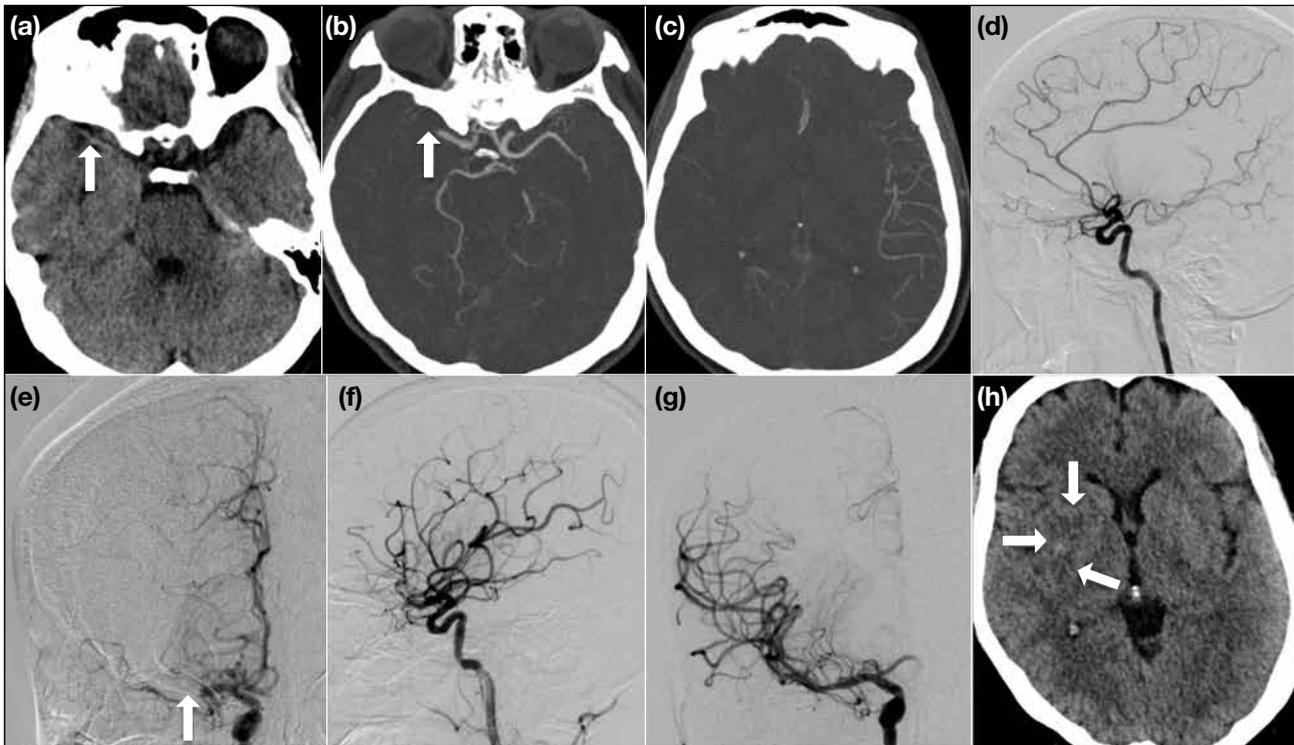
A 56-year-old woman with good past health presenting with acute left-sided weakness and numbness. (a) Plain computed tomography (CT) scan of the brain demonstrated hyperdense right middle cerebral artery (MCA) sign (arrow), suggestive of acute right MCA thrombosis. (b,c) CT angiogram confirmed truncation of right M1 (arrow), with markedly decreased vascularity in right MCA territory and poor collaterals. (d,e) Cerebral digital subtraction angiogram (DSA) showed occlusion of right M1 (arrow) with absent distal flow. Thrombectomy with ADAPT (A Direct Aspiration First Pass Technique), using 5MAX ACE catheter and Penumbra aspiration pump was performed for 2 minutes. (f,g) Post-thrombectomy cerebral DSA showed restoration of the right MCA blood flow with no residual filling defect detected (Thrombolysis in Cerebral Infarction grade 3). Right A1 was taken over by contralateral anterior cerebral artery as confirmed by DSA of the left common carotid artery (not shown). (h) Follow-up plain CT scan of the brain showed only a small area of infarct in the right basal ganglia (arrows). The patient made an uneventful recovery and was discharged 10 days after the stroke, with modified Rankin scale score and National Institutes of Health Stroke Scale score improving from 5 to 1 and 16 to 1, respectively.
